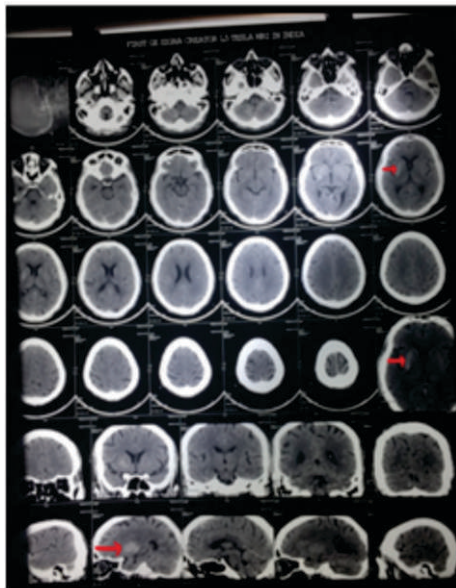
CT head study shows hyperdense right basal ganglia.
